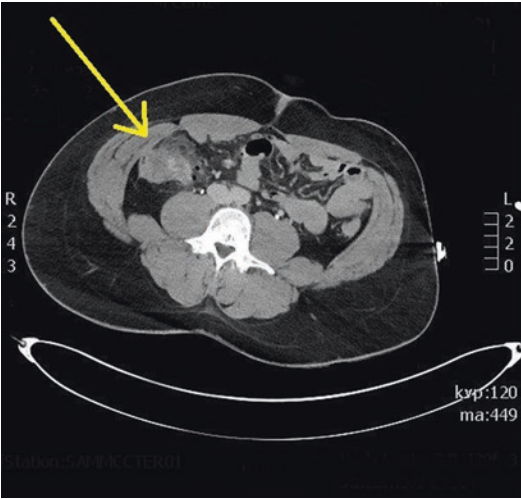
CT image showing extraluminal gas and bowel wall thickening, suggestive of right-sided colonic injury following transabdominal gunshot wound
